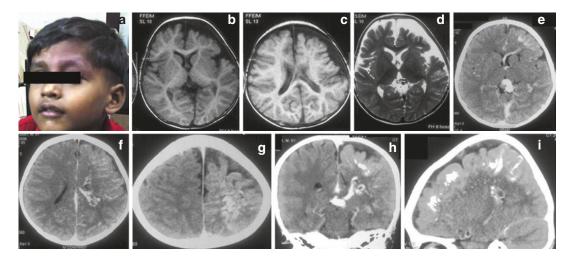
(a) Four-year-old boy presenting with left forehead swelling. (b, c, d) MRI and (e, f, g, h, i) CT scan showing features of venous abnormalities of Sturge–Weber syndrome. (CVMS-1)
